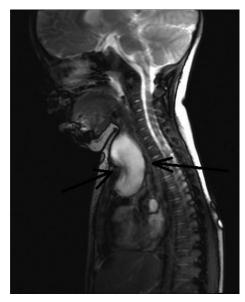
Magnetic resonance imaging (MRI) of the tumor mass
